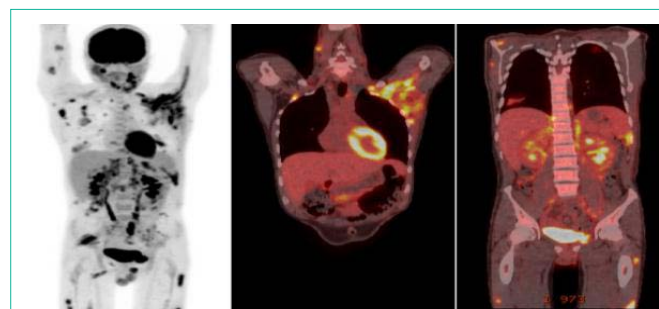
20 yo gentleman with HLH. FDG PET scan showing multiple FDG avid lesions noted involving muscles and subcutaneous tissues in the face, arms, chest, abdomen and lower extremities. FDG avid lung nodules and mild diffuse bone marrow uptake is also noted. Ferritin levels elevated at 13,500. Patient passed away within a few weeks of initial diagnosis.
